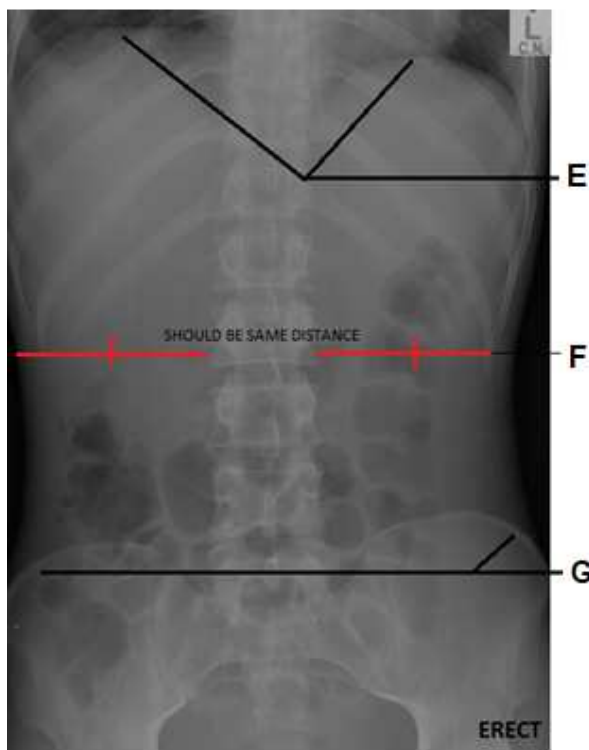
Erect abdomen radiograph
